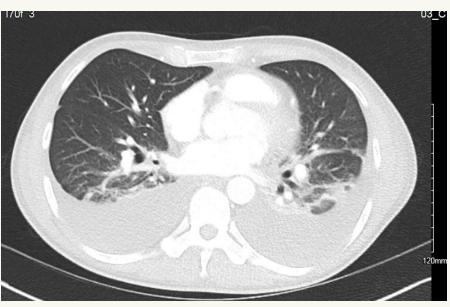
CT of the thorax
